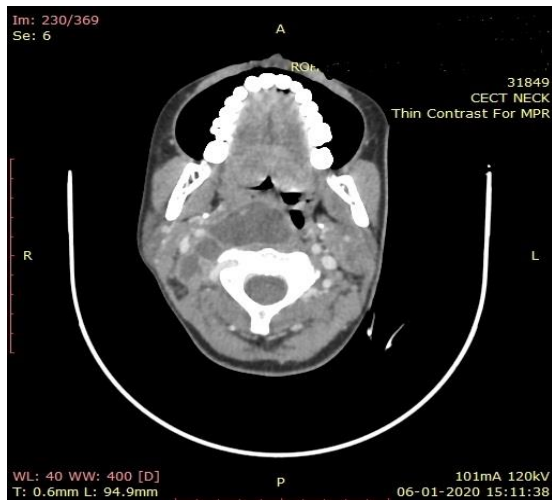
CT Scan Axial view showing defined peripherally enhancing lesion in the retropharyngeal region.
